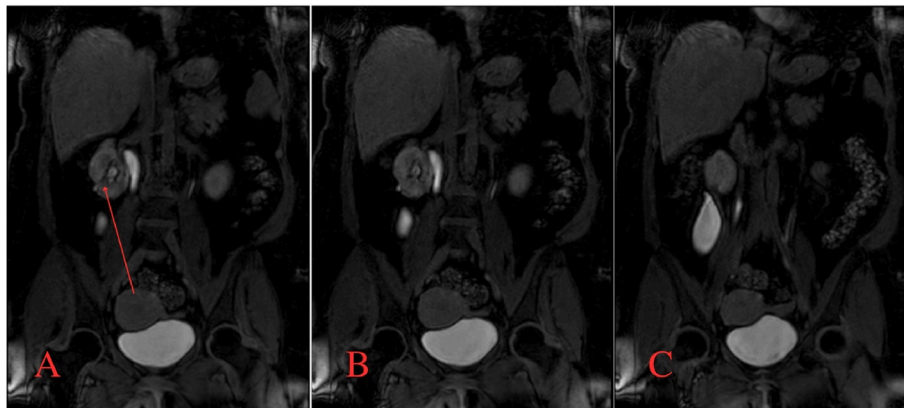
Coronal plane of post-contrast infusion MRI displaying a narrow channel with an anterior pathway originating from the kidney's inferior pyelocaliceal system (A) that leads to a large elongated structure that completely fills with contrast (B and C).
